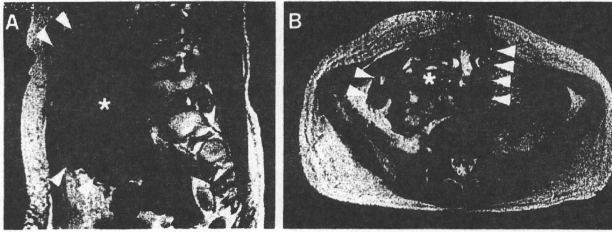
A,B: Abdominal MRI 6 months after the two-step treatment. The arrowhead shows the spacer. The asterisk shows the distinct shrinkage of the tumor.
